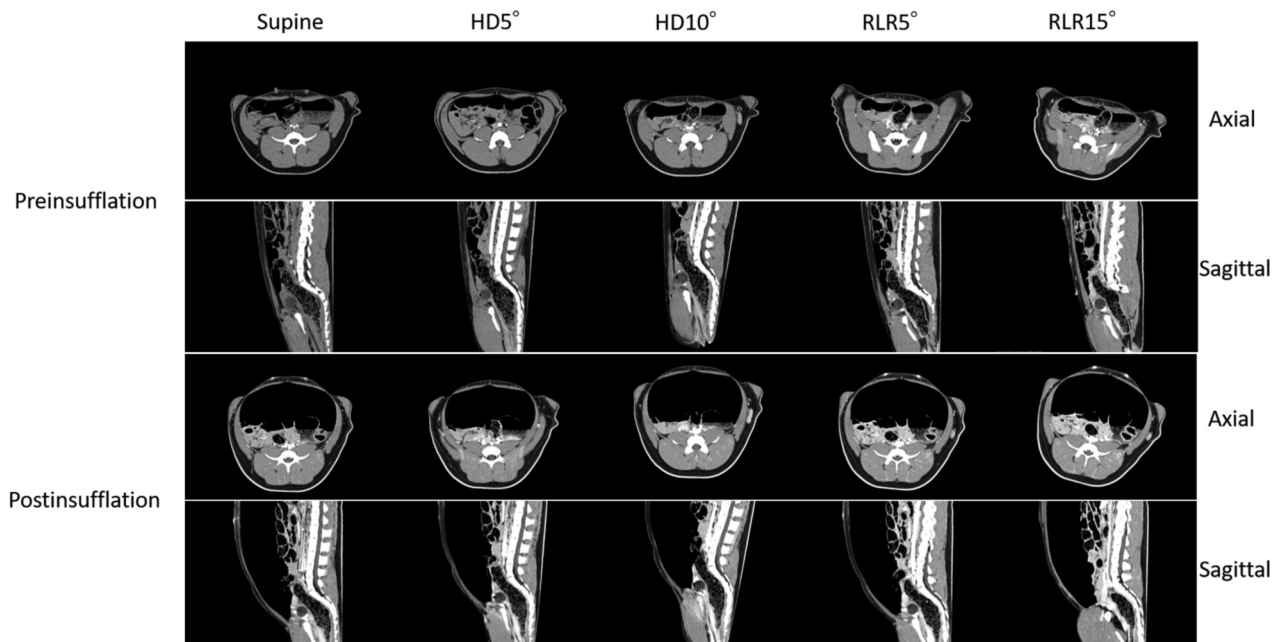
Upper computed tomography images were acquired under different postural changes (supine, HD 5°, HD 10°, RLR 5°, RLR 15°). Lower computed tomography images were acquired under pneumoperitoneum and different postural changes. HD: Head down; RLR: right lateral recumbent.
